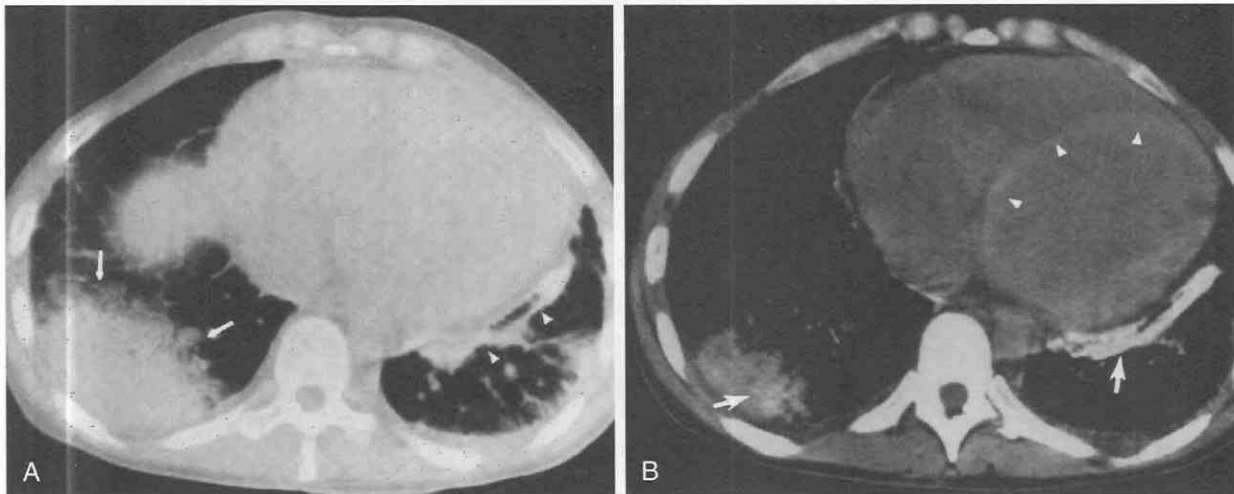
Amiodarone toxicity. *A* and *B*. The patient, a 40-year-old woman with arrhythmias who had been taking amiodarone for 32 months, presented with pleuritic chest pain and shortness of breath. *A*, Noncontrast CT shows a large, wedge-shaped area of consolidation in the right lung base (arrows). A band of atelectasis is noted adjacent to the left heart border (arrowheads). *B*, Both areas demonstrate high attenuation on soft tissue window settings (arrows). The increased attenuation of the heart muscle is a result of amiodarone deposition (arrowheads). (From Kuhlman JE, Tergen C, Ren H, et al: Amiodarone pulmonary toxicity: CT findings in symptomatic patients. *Radiology* 177:121-125, 1990.)
